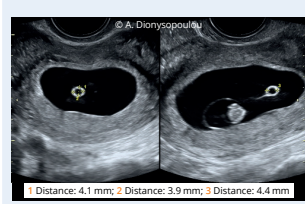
Yolk sac (transvaginal sonography)
